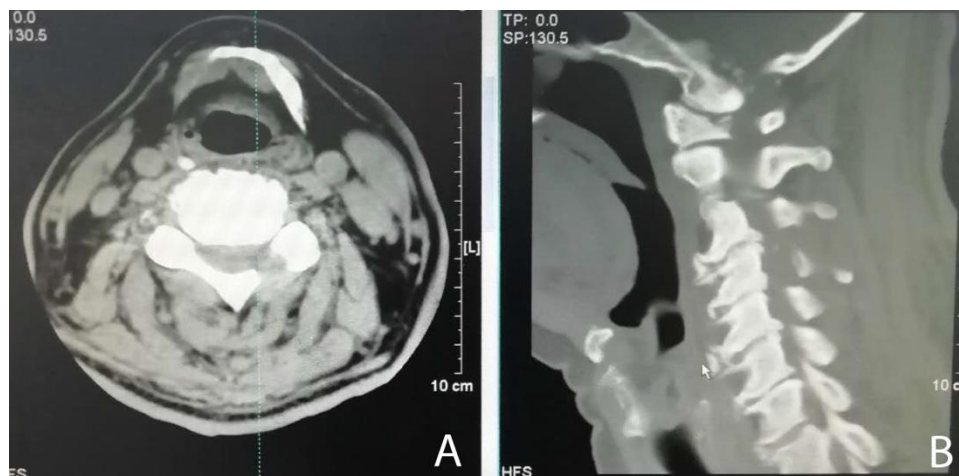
Postoperative cervical CT scan. (A) Cross-section: Left lateral laminectomy was performed in 4/5 segments, leaving the left facet joint intact. (B) Sagittal plane: the left lateral lamina of the neck 4 was completely removed, and the lower edge of the cervical 3 and the left margin of the cervical vertebra were removed.
